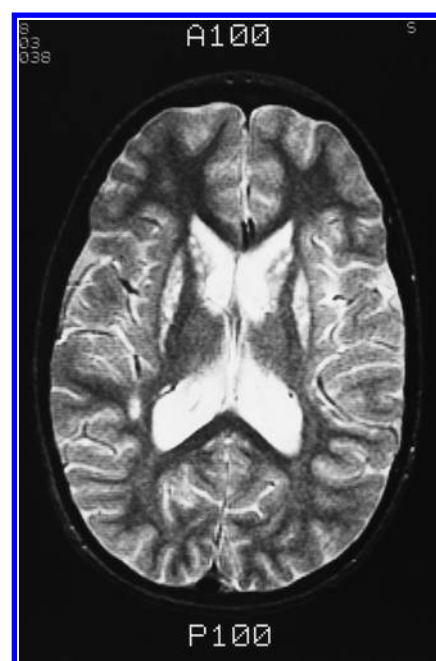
MH: Neuroimaging (magnetic resonance imaging) of the brain reveals an extraordinary pattern of increased T_2 signal in the white matter.
